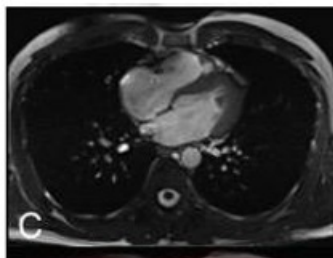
Axial MRI T2 True FISP weighted image of the chest.
